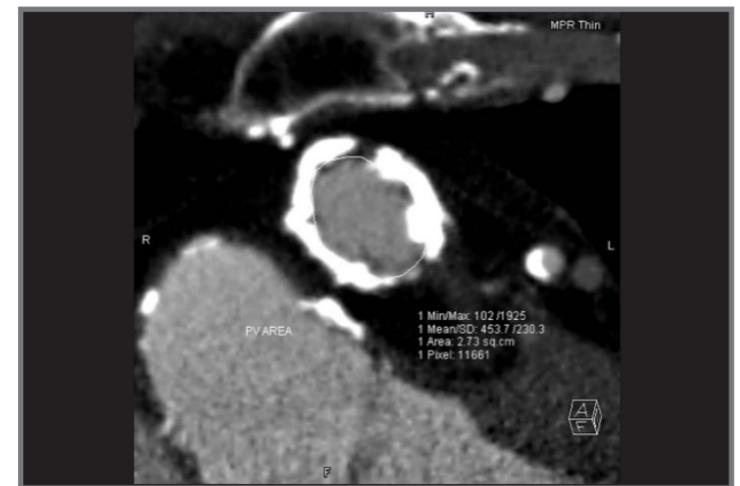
CT angiographic image with planimetric measurement of the effective area of the calcified pulmonary homograft.
